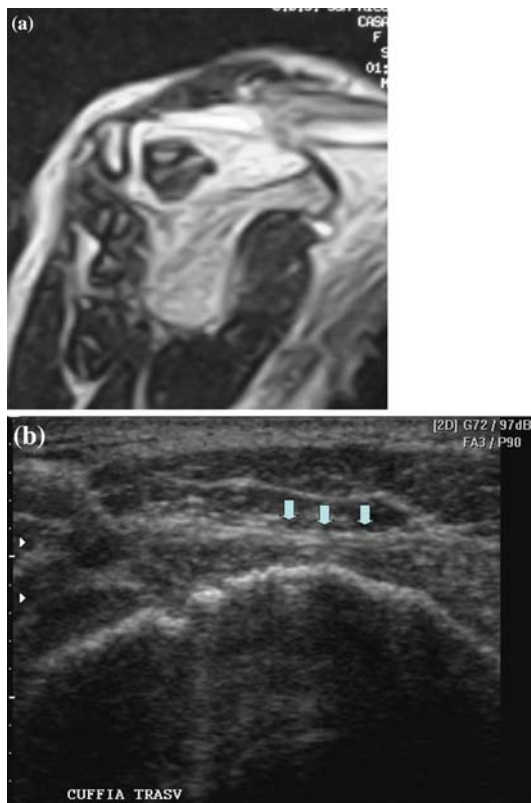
a Pre-operative MRI showing a grade III degenerative fatty infiltration of supraspinatus tendon. b Postoperative ultrasound images of the same patient at follow-up shows a re-tear of tendon (arrows)
